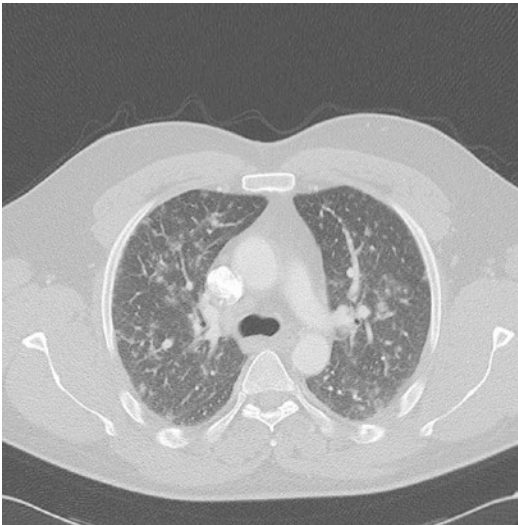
Same patient as in Fig. 24: CT showing bilateral 5–10 mm nodules of soft tissue density and a ground-glass halo
